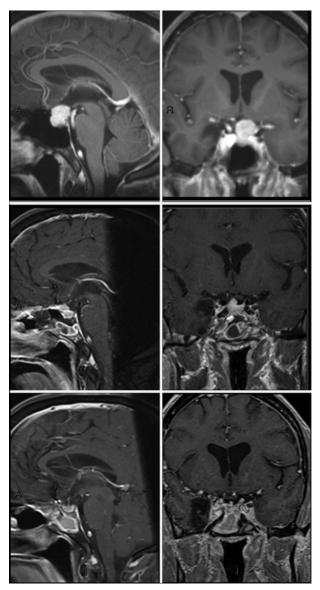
Sagittal and coronal Gd-enhanced T1-weighted MR images showing the preoperative (upper) and postoperative (center) tumor volumes and after radiotherapy (lower).
